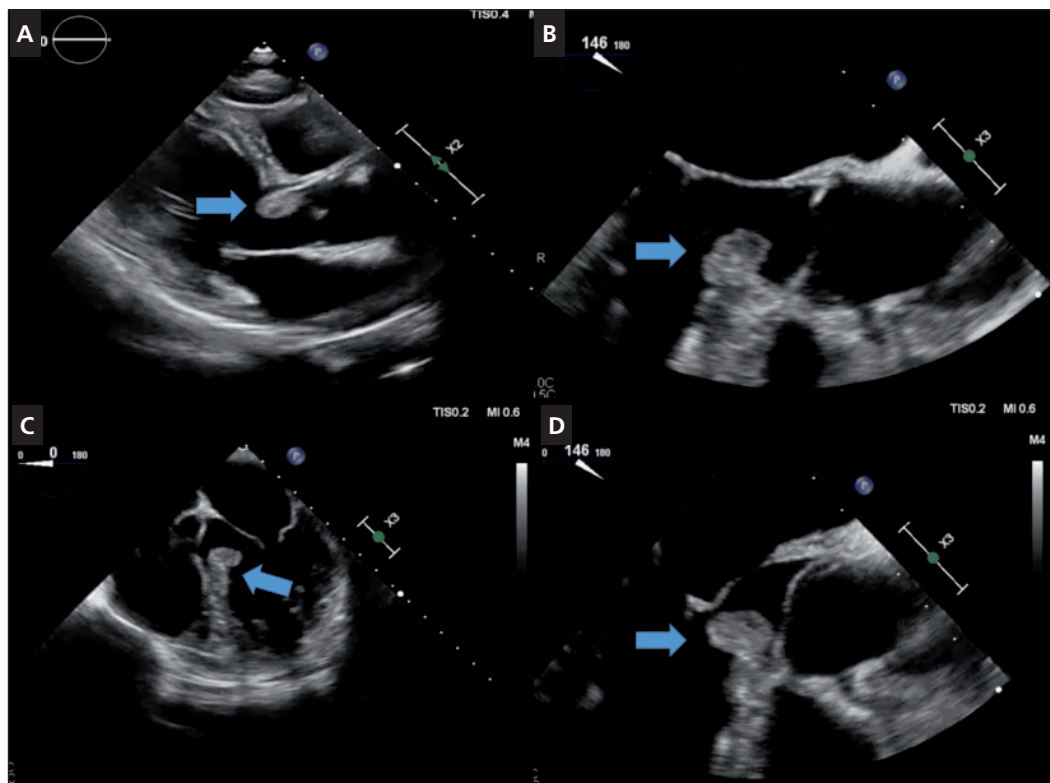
(A) Parasternal long axis view of the mass in LVOT (arrowhead). (B) Zoom LVOT view of the mass on TEE (arrowhead). (C) Apical four chamber mid septum view of the mass (arrowhead). (D) Zoom LVOT view of the mass on TEE (arrowhead). LVOT – left ventricular outflow tract; TEE – transesophageal echocardiography.
